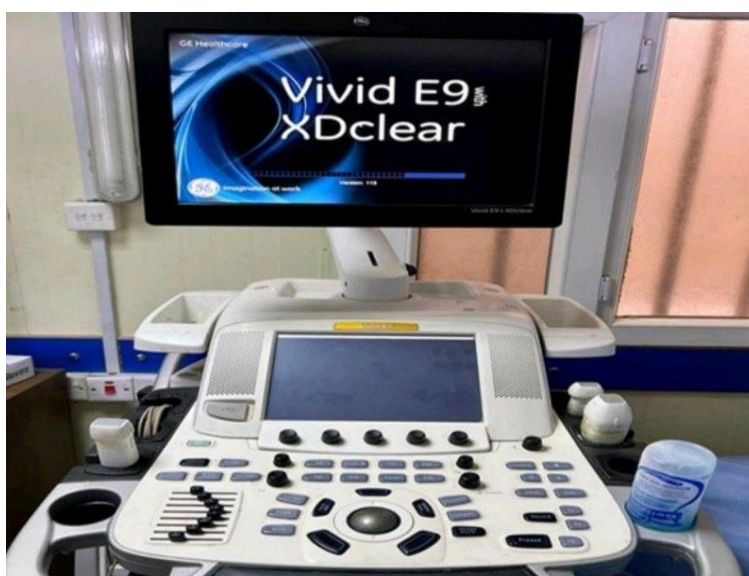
Echocardiography Vivid E9 Xdclear GE device
